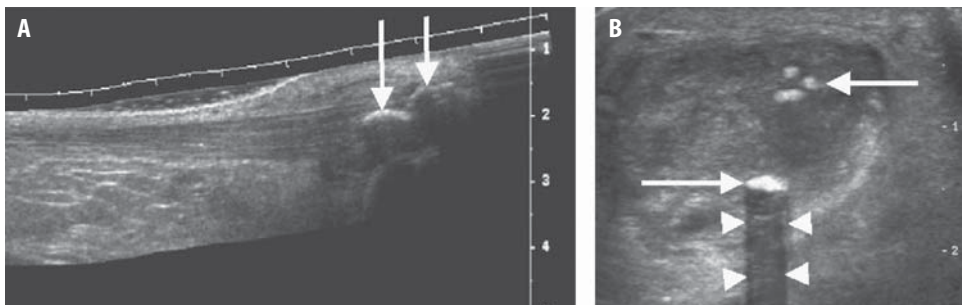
(A) Longitudinal extended field of view ultrasonographic image of an insertional Achilles tendinosis with echogenic (bright) calcification (solid arrows) in the thickened distal Achilles tendon. (B) Transverse ultrasonographic image of a previously
